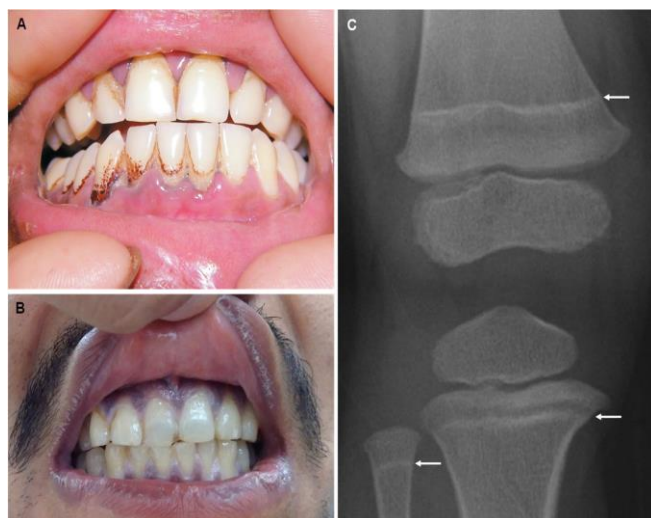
Features of Burton's line that are emphasised by deposits (A)⁵⁷, blue- purplish discoloration of gums (B)⁵⁸, and X-ray with arrows showing "lead lines" (C)⁵⁹.
